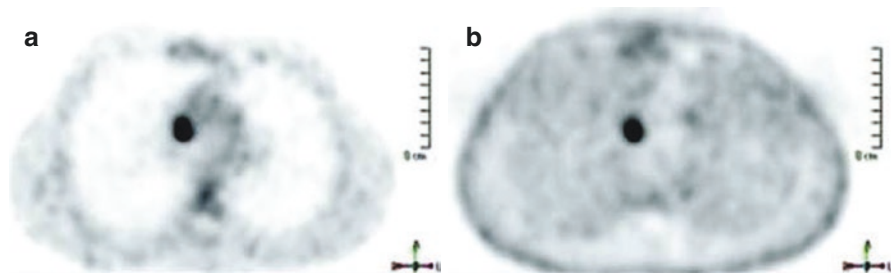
Pretreatment PET-CT (a) reveals FDG-avid right paratracheal lymph node in a teenager after lung transplantation. Posttreatment study (b) reveals resolution of the FDG avidity and diminution of the node. (Courtesy of Dr. David Manson, Hospital for Sick Children, Toronto)
